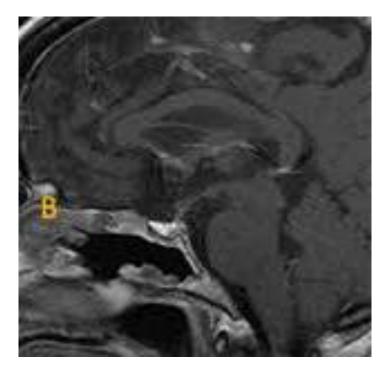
MRI – AFTER SURGERY
